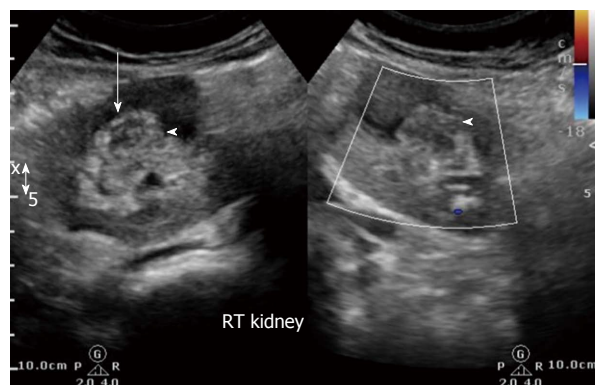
Initial ultrasound image reveals heteroechoic indeterminate renal sinus/renal pelvic lesion (white arrow). Doppler revealed negligible vascularity.
